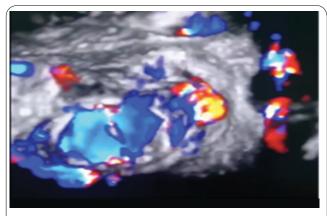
3D Transesophageal echocardiogram with severe paraseptal mitral paravalvular leak.
